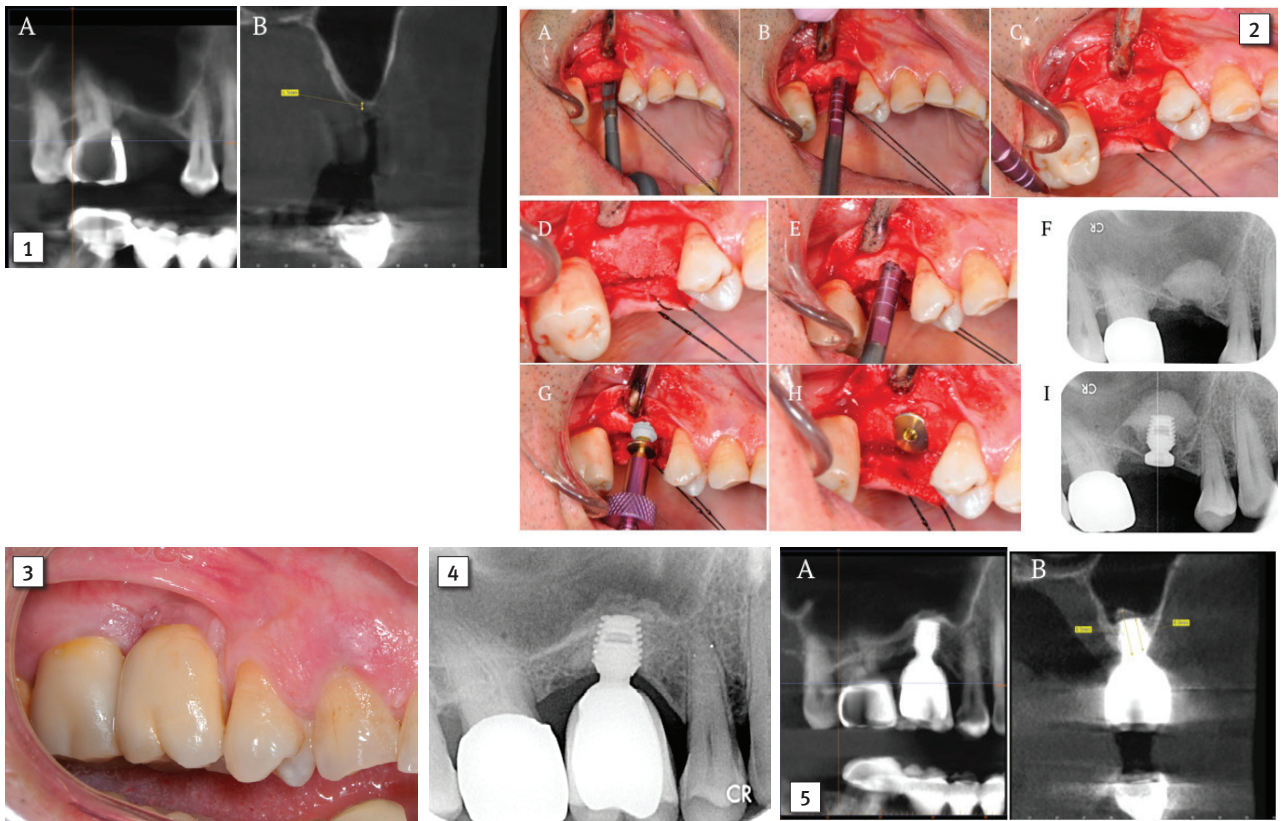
Vertical and horizontal residual bone on CT scan.
